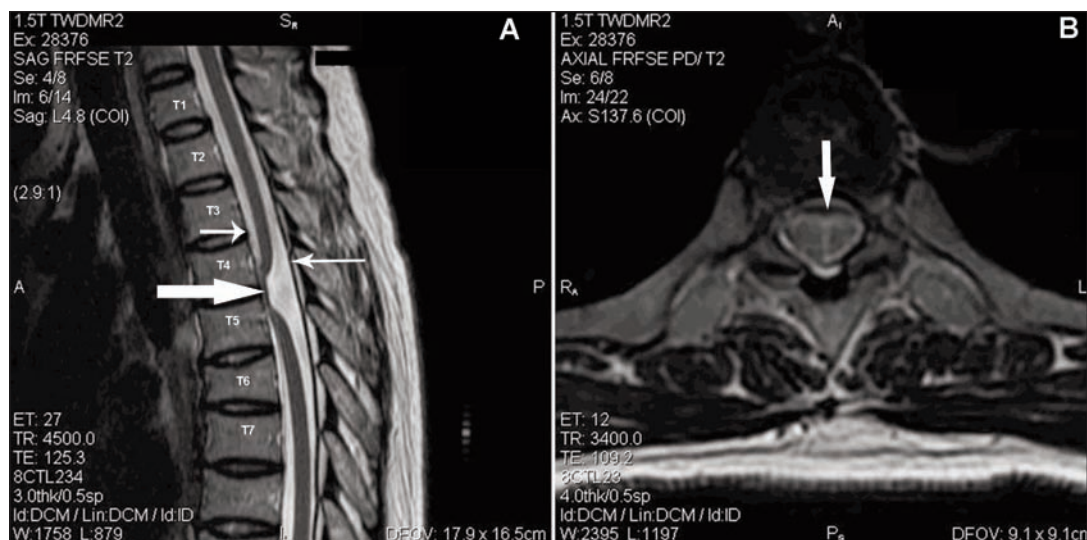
A, B. Preoperative midsagittal and axial T2-weighted magnetic resonance image demonstrating a ventrally displaced spinal cord with focal herniation through the dura at T4-5. No associated cord signal changes or syrinx was present. Focal myelomalacia is present as a result of chronic pressure (big arrow). Ventral dura (Small arrow facing right). Dorsal dura (small arrow facing left). Ventral defect (Down-facing arrow).
